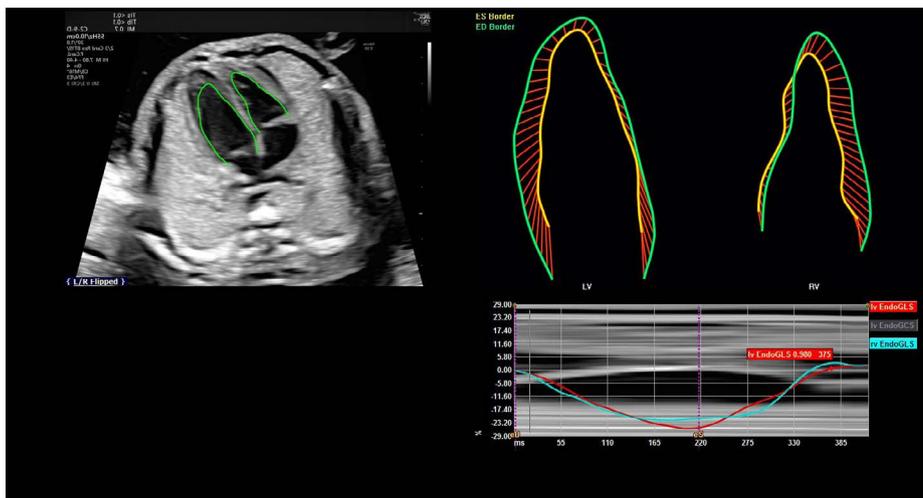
Analysis of fetal heart function with Fetal HQ (used with permission of GE Healthcare). This tool, previously utilized in adults only, allows automatically tracking and measuring strain while performing a fetal echocardiogram by segmenting the heart in many small elements and analyzing directions and intensities of the various movement vectors. This furnishes simultaneous information on the size, shape and function of the fetal heart.
